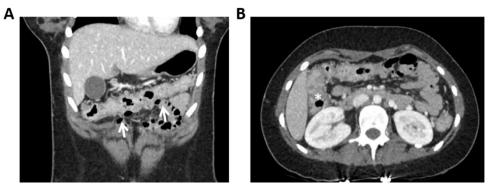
CT scan showing colitis extended to transverse colon (A, arrows) and hepatic flexure (B, *).
